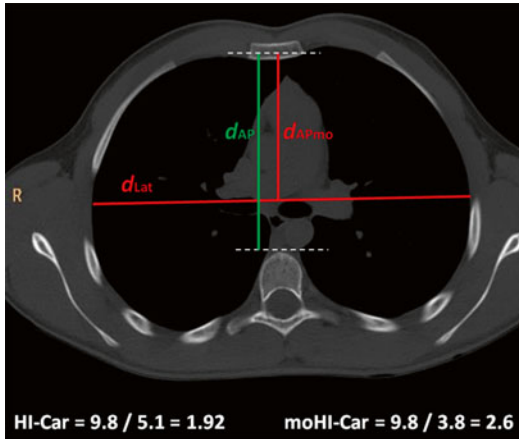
Haller Index for Pectus Carinatum: the widest transverse diameter [$dLAT$] is divided by the highest antero-posterior distance [dAP]. Chest CT Haller Index adapted for pectus carinatum: the widest transverse diameter [$dLAT$] divided by the distance from the central chord to the under surface of the maximal protrusion [$dAPmo$]
